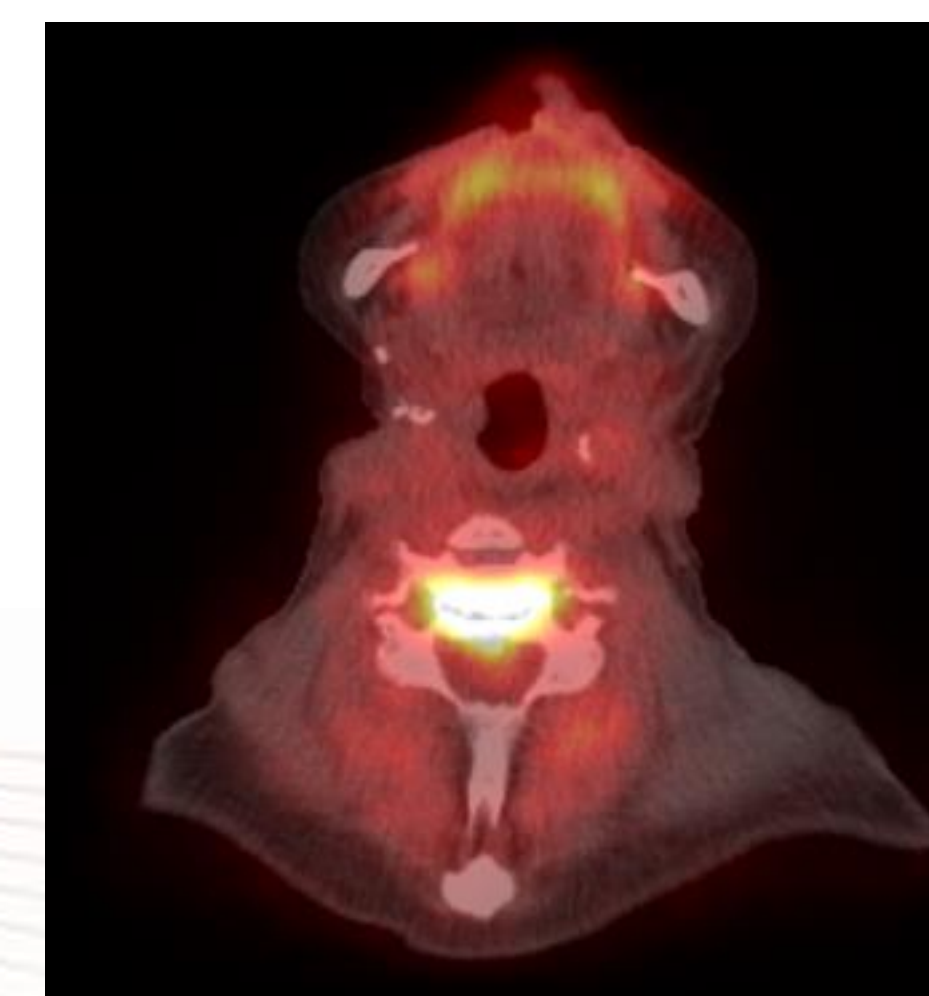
PET/CT Axial View showing hypermetabolic uptake at C5-6
